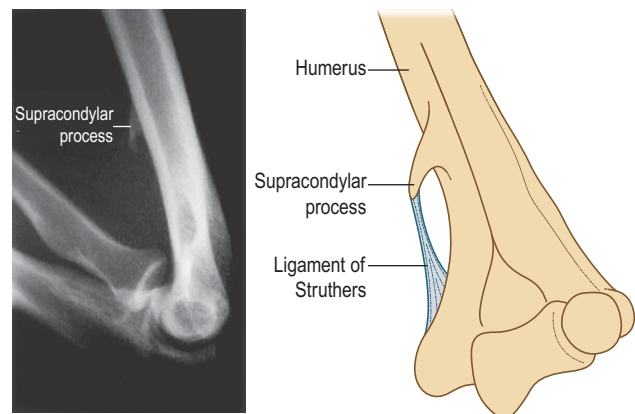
Ligament of Struthers. Rare individuals have a supracondylar bony spur from which a tendinous band (ligament of Struthers) runs to the medial epicondyle. The median nerve and brachial artery travel under this ligament. The supracondylar process can be demonstrated by plain bone X-ray films. (Adapted from Struthers, J., 1854. On some points in the abnormal anatomy of the arm. *Br Foreign Med Ch Rev* 13, 523–533.)
